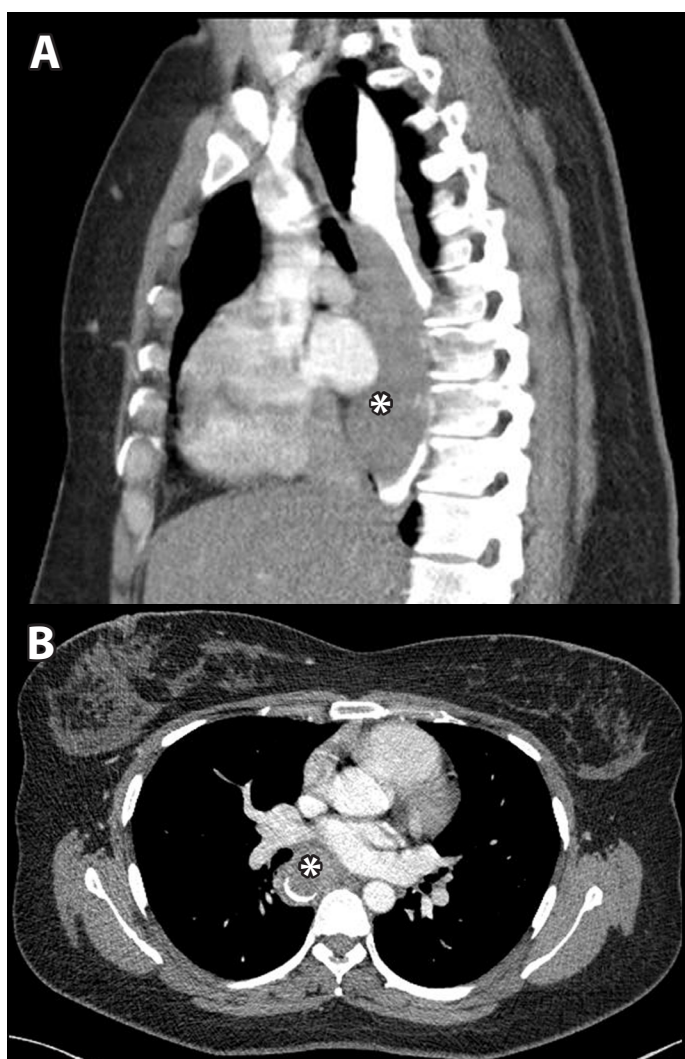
Sagittal (A) and axial (B) computed tomography (CT) images of the thorax oral administration of contrast medium: large elongated intramural hematoma (star) narrowing esophageal lumen.
